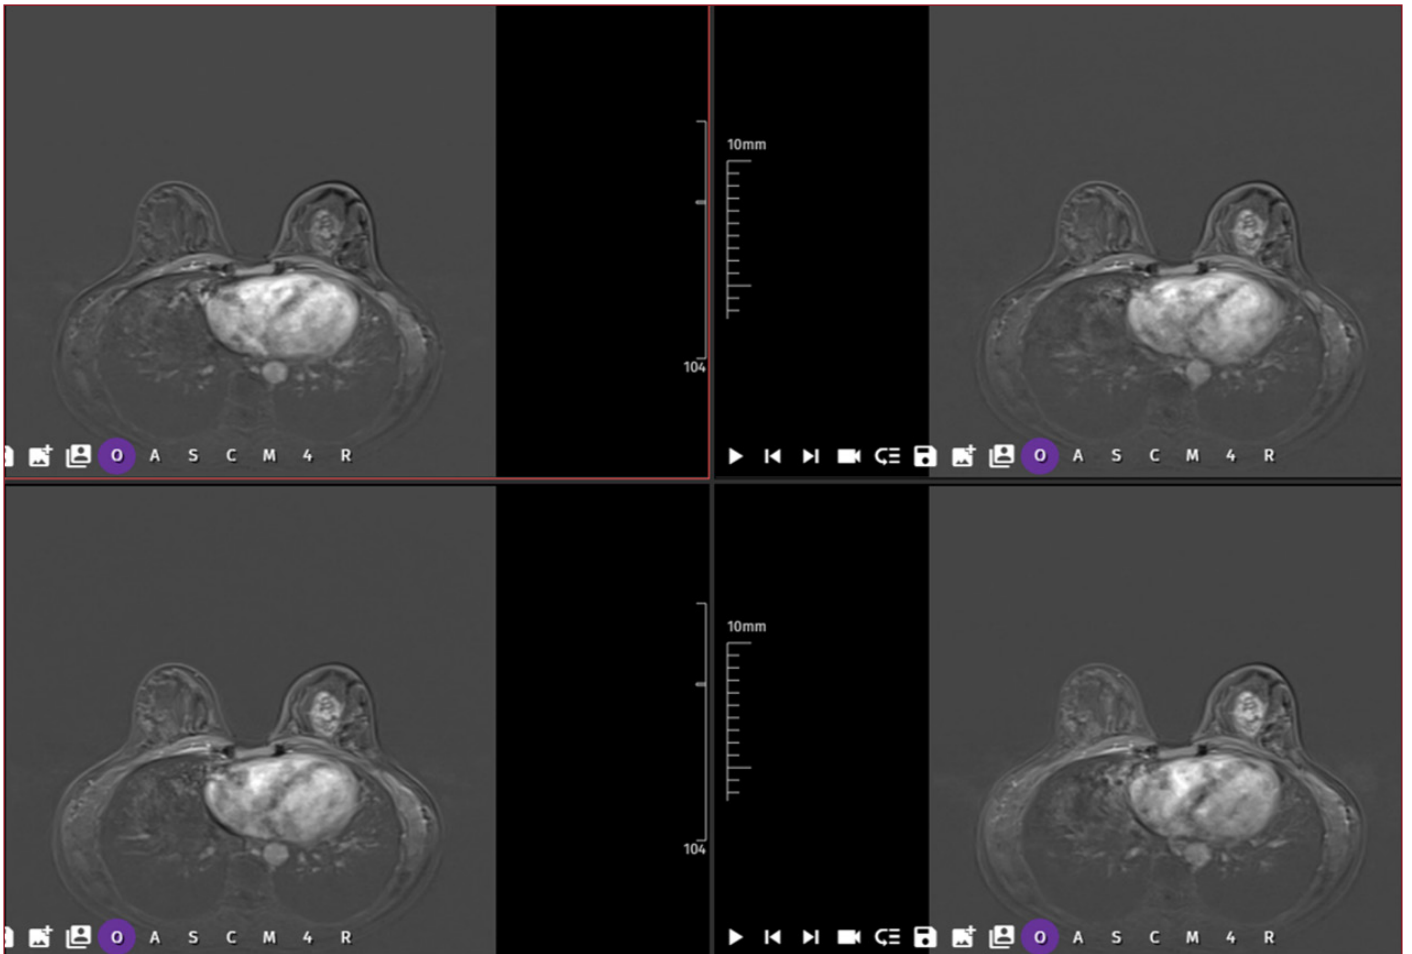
On contrast-enhanced MR images, the lesion shows heterogenous and persistent enhancement
